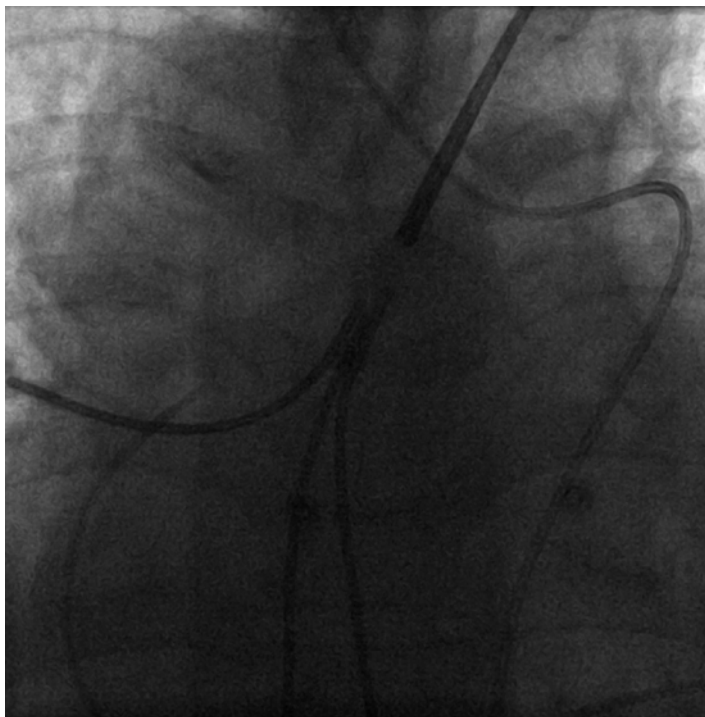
Plain radiograph showing a right heart catheter in the pulmonary artery of a patient with dextrocardia (precordial leads also shown)
